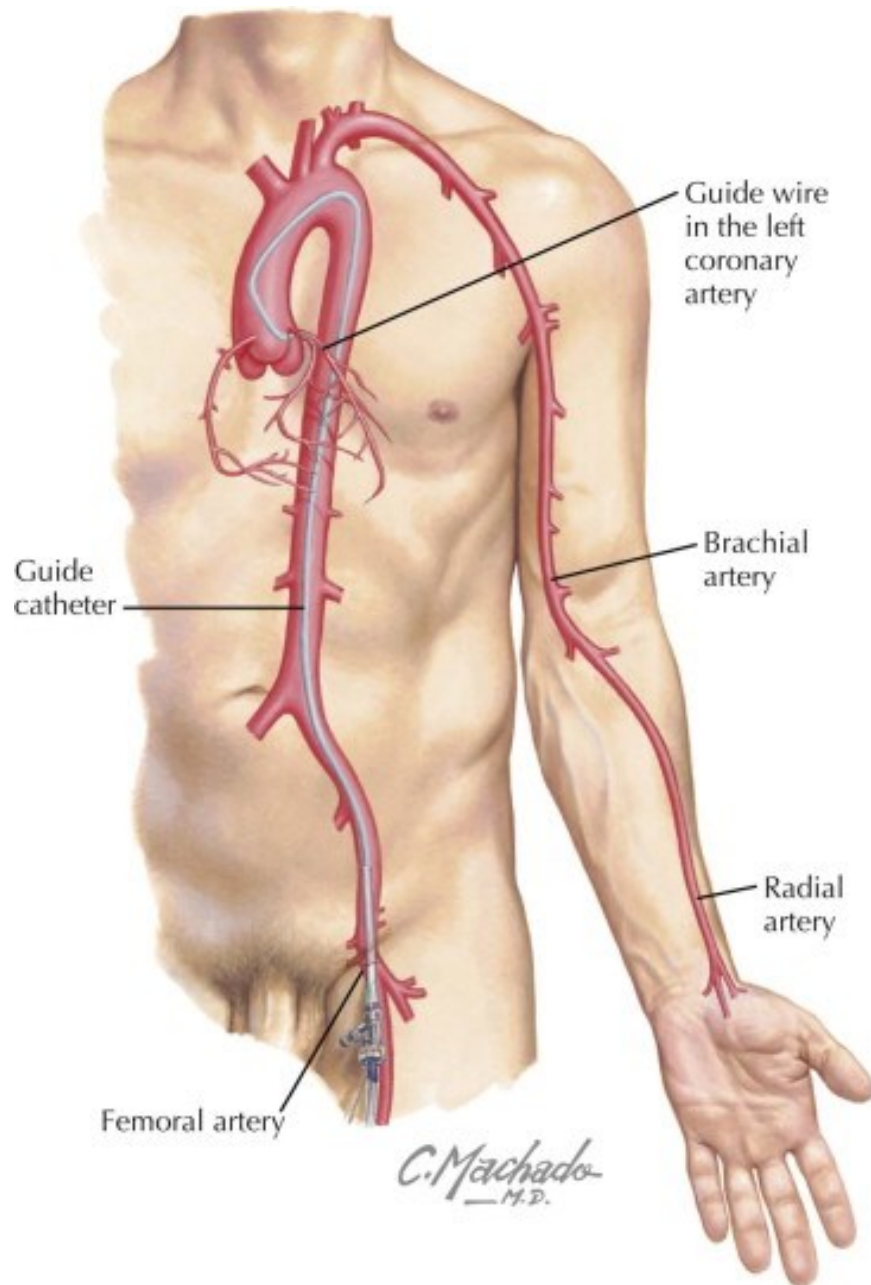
Percutaneous coronary intervention: vascular access [20]. PCI is performed via the femoral, radial, or brachial artery access with the same radiographic equipment used for diagnostic coronary arteriography in cardiac catheterization laboratories. The most frequently chosen artery access is the femoral artery, and it is the preferred approach applied in most clinics [20].
